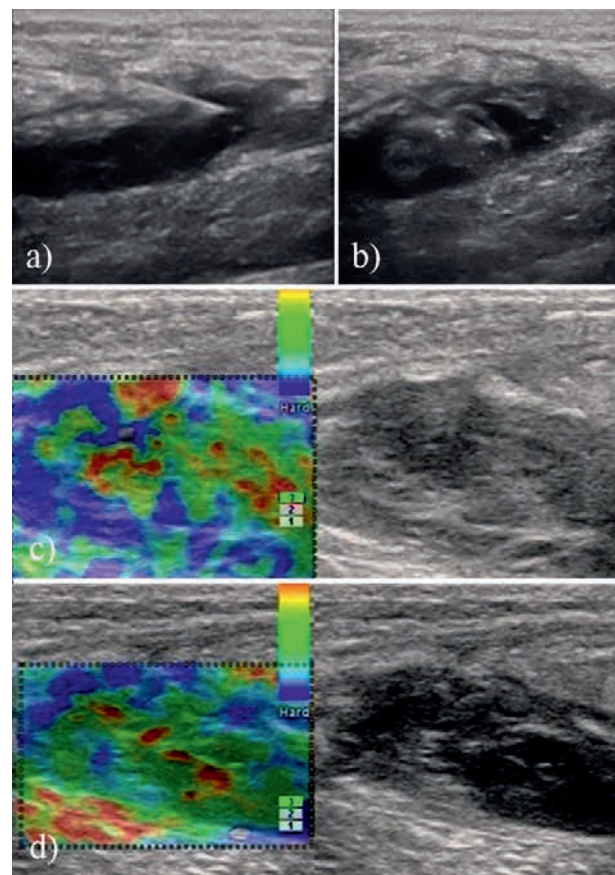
A professional football player, 22 years old. Postrauma hematoma of the left thigh: a) hematoma aspiration under ultrasound guidance, longitudinal scan; b) PRP administration; c) sonoelastography on 7th day – the hematoma was replaced by heterogeneous tissue with a predominance of dense component corresponding to fibrosis; d) sonoelastography on 14th day- the elasticity of the regenerating tissue is growing comparing with 7th day examination
